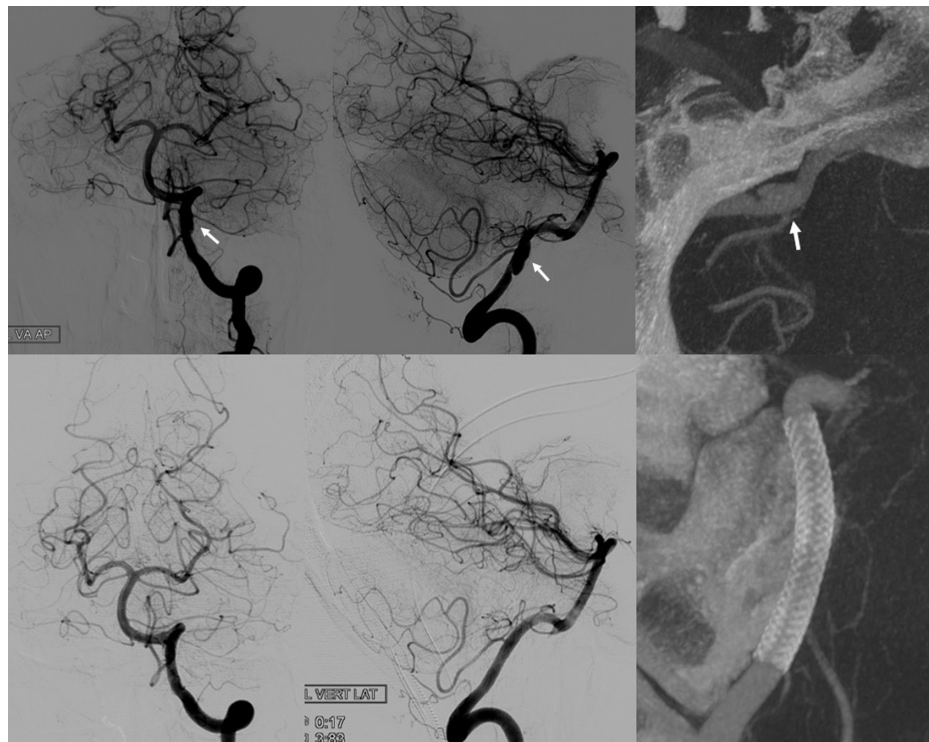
Images from a 55-year-old man with a VA dissecting aneurysm. AP and lateral left vertebral angiogram shows the dissecting aneurysm (arrows) in the intracranial segment of the left VA. Flat panel detector CT angiography image of the dissected segment of left VA and associated pseudoaneurysm. The left PICA (arrow) arises from the posterior wall of the dissected segment of VA. AP and lateral left vertebral angiogram demonstrates the reconstruction of the left VA following the endovascular treatment with a flow diverter stent. DSA, digital subtraction angiography; CT, computed tomography; VA, vertebral artery; AP, anterior-posterior; PICA, posterior inferior cerebellar artery.
